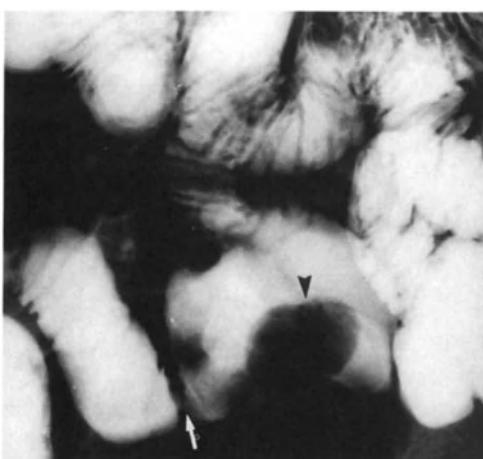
Lipoma demonstrated by enteroclysis. A rounded intramural submucosal defect is seen in the mid small bowel (arrowhead) which at surgery proved to be an ulcerated lipoma. Other benign small bowel tumors look similar. Lipomas, however, appear to be more compressible. Attenuation of larger lipomas can be accurately depicted by CT.
